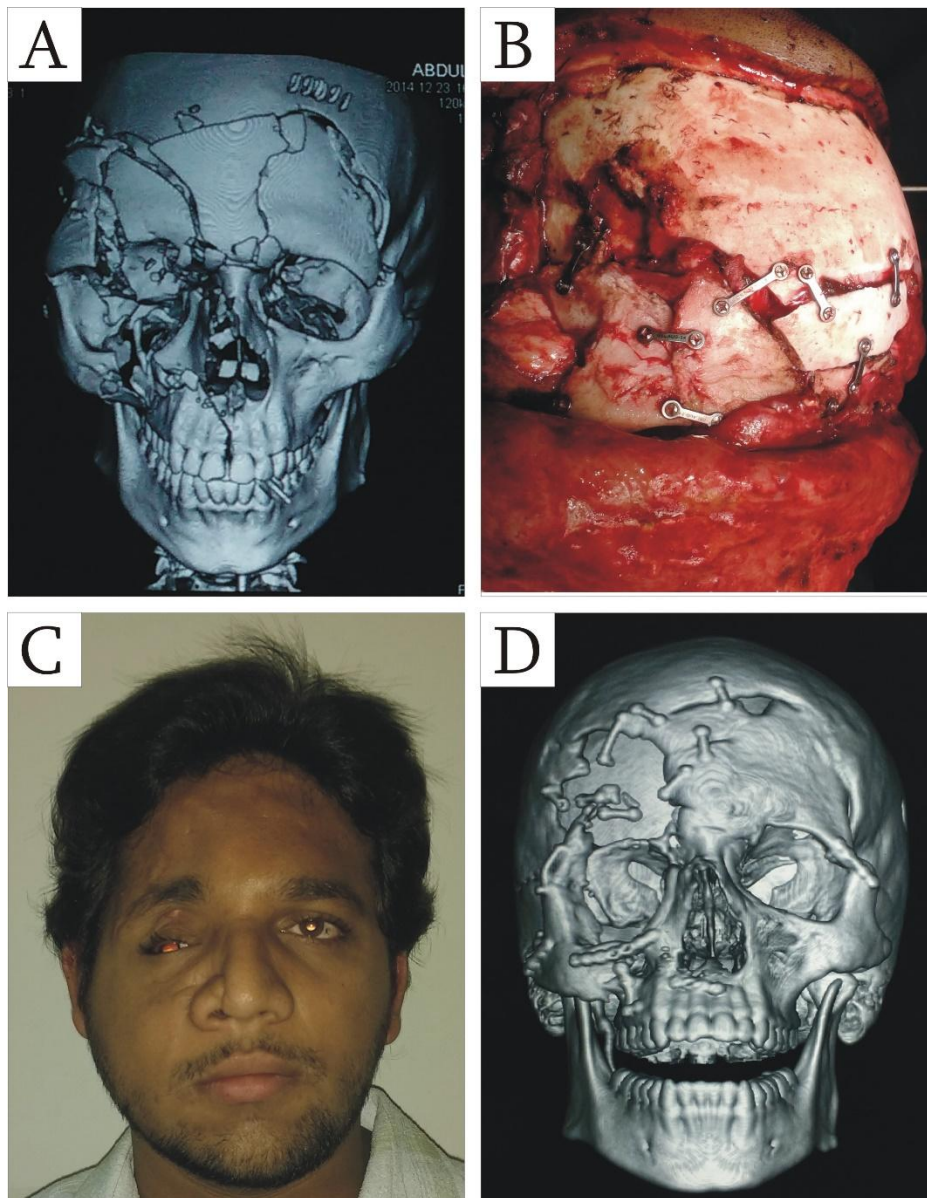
A – Post trauma 3D reconstruction. B – Cranioplasty using autologous comminuted frontal bone fragments secured using miniplates during the 1st surgery. C – 1 year post-operative clinical photograph after the 1st surgery. D – 1year post-operative CT scan 3 D reconstruction showing total resorption of the frontal bone fragments.
